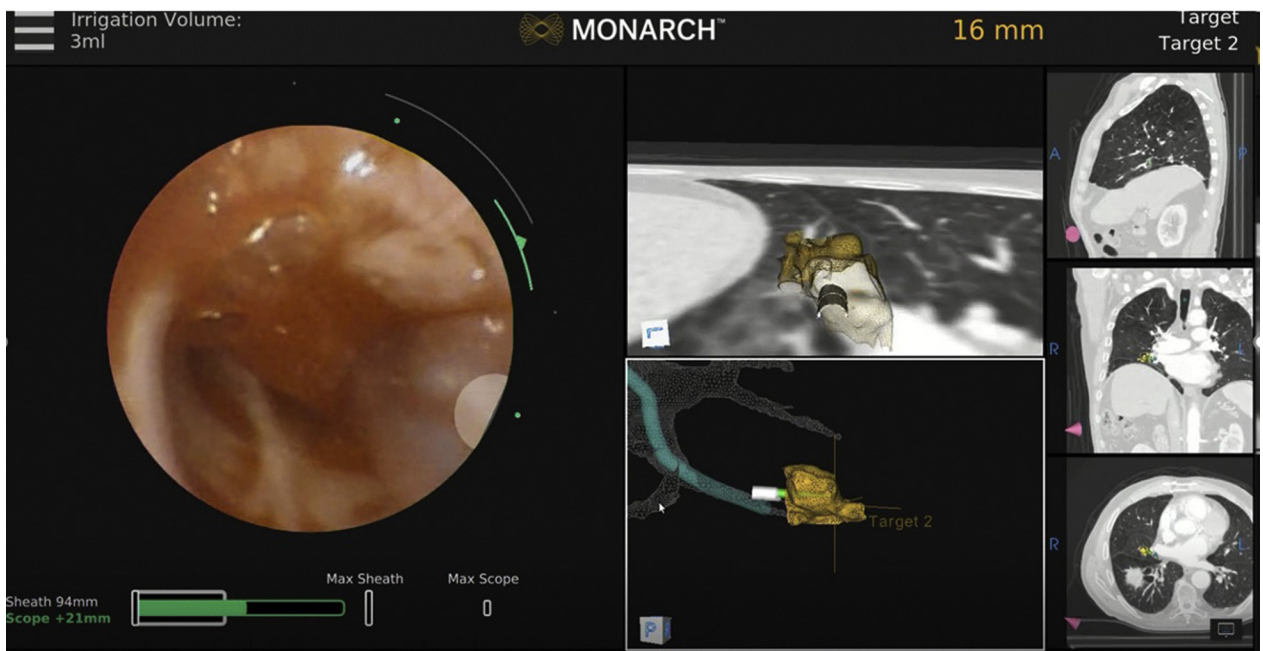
Robotic system user interface shows live bronchoscopic, electromagnetic navigation bronchoscopy with targeting, and multiplanar CT views.
